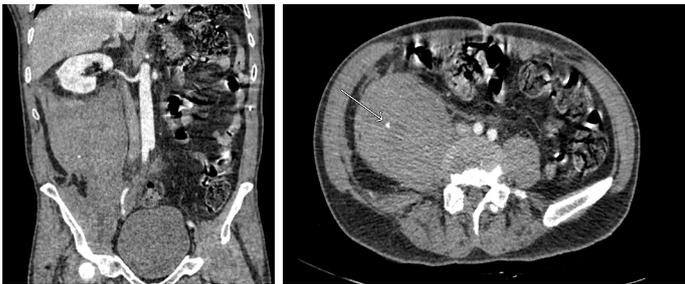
A- A 55-year-old male patient; hematoma in the right retroperitoneal space was demonstrated in both abdominal and pelvic CT scans
